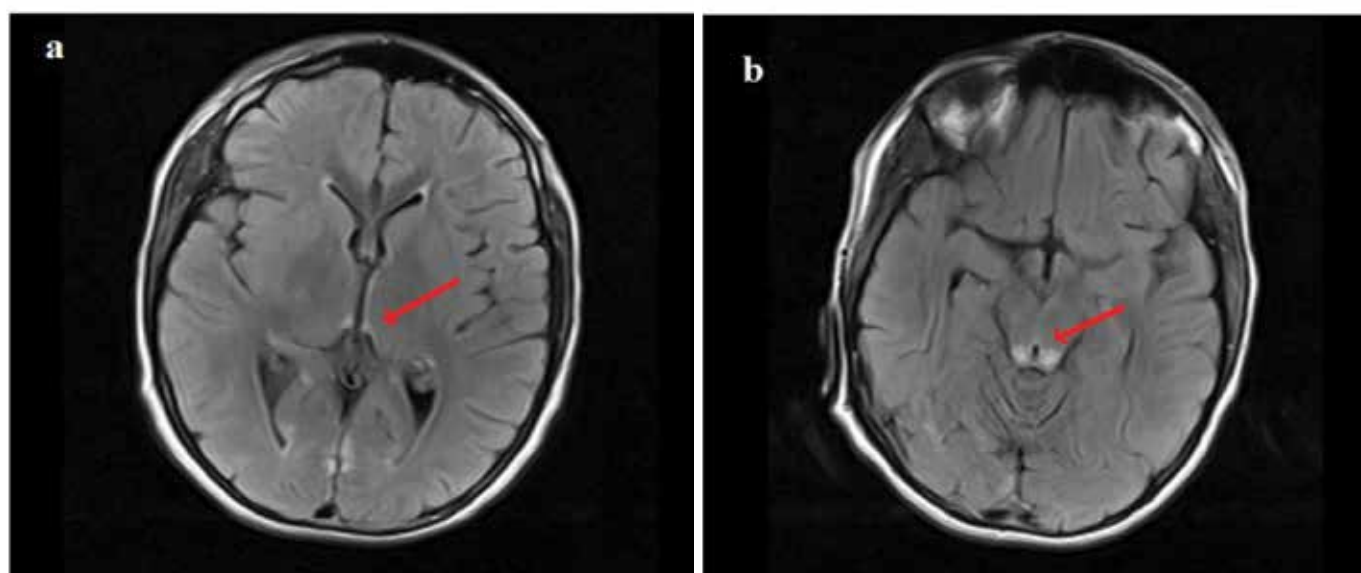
Brain MRI findings: (a) increased signal intensity on flair in dorsomedial aspect of both thalami. (b) increased signal intensity on flair in dorsal aspect of medulla oblongata, midbrain tectum.
